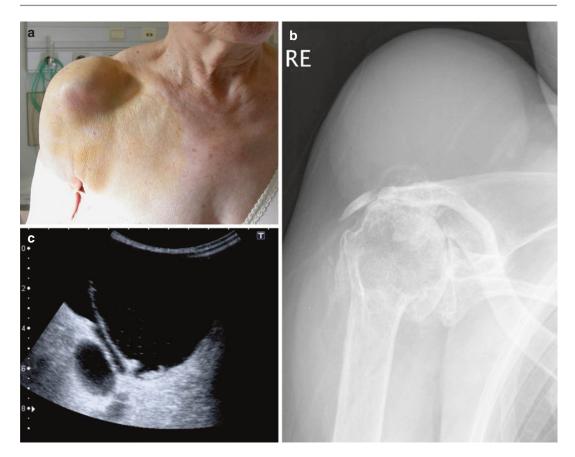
Geyser phenomenon in a long-standing rotator cuff tear: (a) clinical image showing a patient presenting with a soft mass on top of the AC joint, (b) plain radiograph of the right shoulder showing marked narrowing of the acromiohumeral space, in keeping with a large
